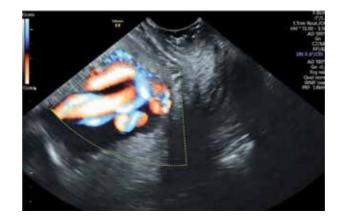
Ultrasound color Doppler image showing vasa praevia.
